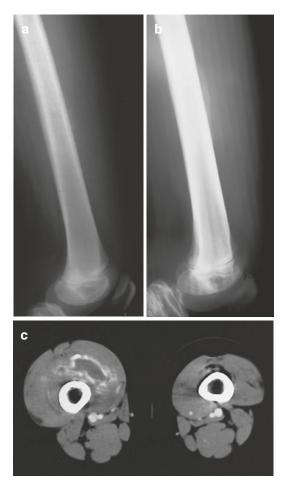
(a–c) Myositis ossificans, intermediate stage of the right thigh in a 13-year-old boy: (a) plain radiograph a few days after trauma, (b) plain radiograph 5 days later, and (c) CT. Presence of a faint linear periosteal calcification on the ventral aspect of the right thigh (a). Five days later there is extensive calcification within the quadriceps muscle (b). On CT there is diffuse swelling of the right thigh with an eggshell calcification within the vastus intermedius muscle (c). The zoning phenomenon is characteristic for an intermediate stage of posttraumatic myositis ossificans
